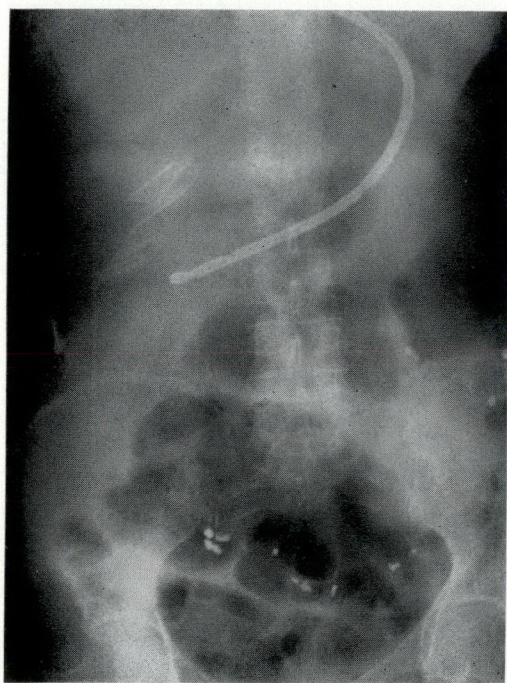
Postoperative radiograph of the nasogastric tube and attached pressure detecting units positioned within the stomach.
